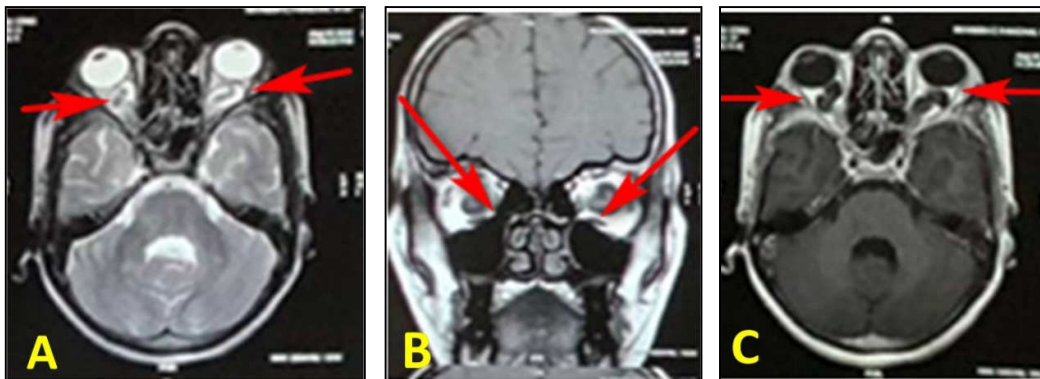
Magnetic resonance imaging(MRI) of brain with orbit showing enlarged optic nerves, optic chiasma and optic tracts on both side and widening of optic canals.
